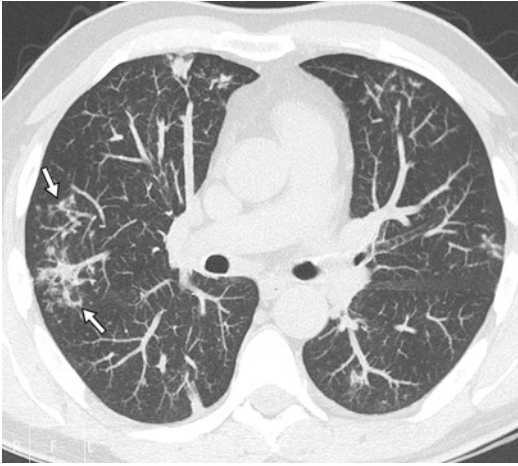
Endobronchial tuberculosis in a 54-year-old man with Hodgkin disease. CT scan shows multiple ill-defined nodules with a tree-in-bud appearance (arrows)
